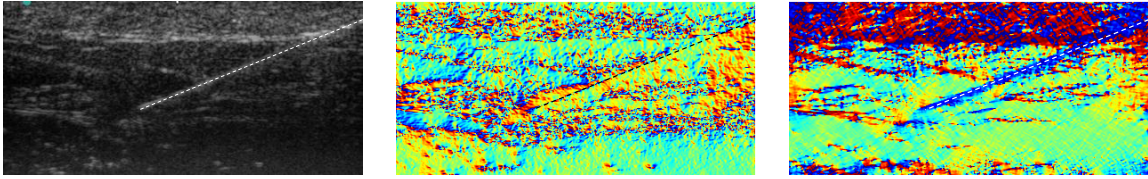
Ultrasound image with biopsy needle (left). Calculated local orientation for monogenic signal (middle) and 2D analytic signal (right). Center line of the needle is indicated with the dashed white and black line, respectively.
